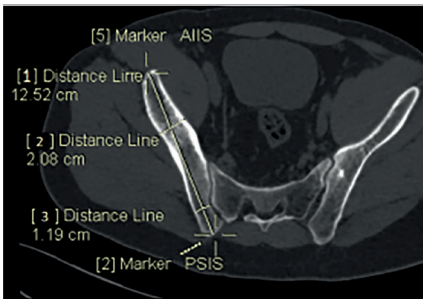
Path A [PSIS to AIIS]. Double oblique reformatted CT image showing Path A trajectory; where [1] represents its length, while [2] and [3] represent width of its narrowest zones, [2] being anterior to [3].
